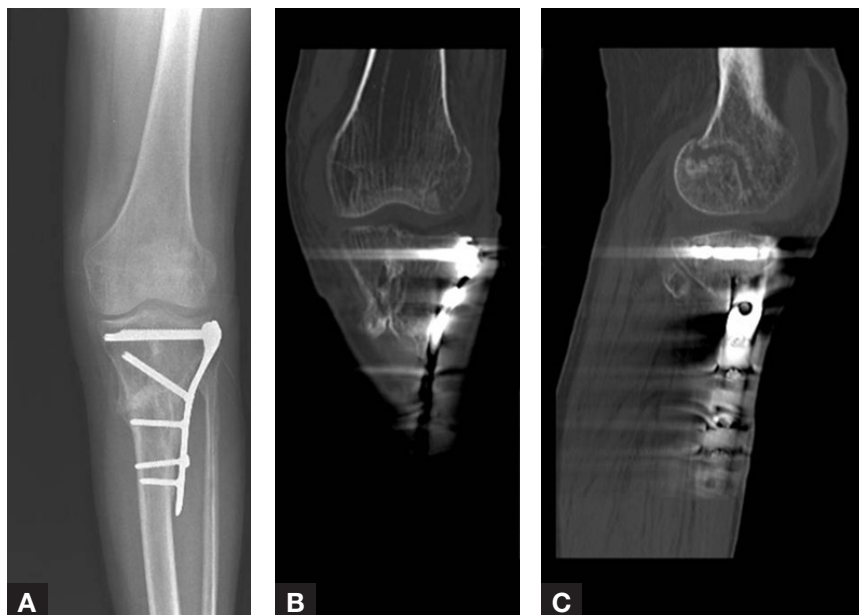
Radiographic (A) and computed tomography (B,C) evaluations of 53-year-old woman, with previous history of trauma requiring surgical fixation to left proximal tibia, who sustained minimally displaced intra-articular left lateral femoral condylar fracture.
